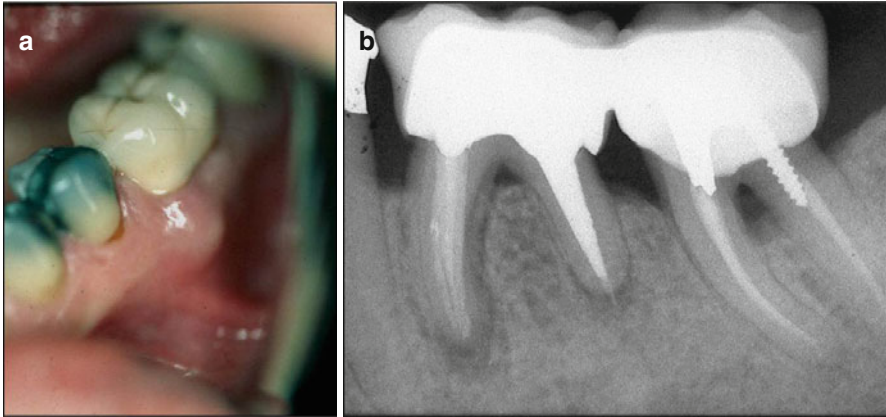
(a, b) A patient with severe periodontal problems who was evaluated for periodontal surgery arrived at the office with a small swelling adjacent to the mesial root area (a). The mandibular left first molar was endodontically treated 7 years previously and restored afterward. Probing depth around the tooth was 5 mm in the midbuccal and 4 mm in the mesiobuccal area. The radiographic appearance of the radiolucency around the mesial root which most likely was of an endodontic origin (b) and swelling in the gingivae adjacent to the mesial root pointed to a VRF. However, in this periodontally involved patient, the final diagnosis was an acute apical abscess (Courtesy Dr. J Halpern)
